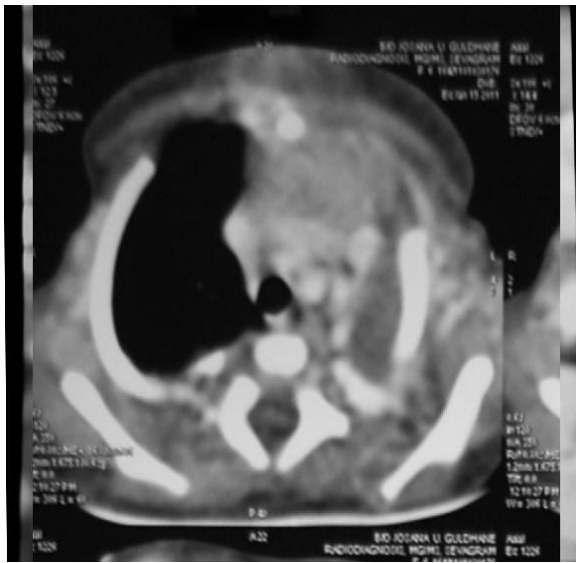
A computed tomography scan of chest - left upper lobe with multiple non enhancing variable sized fluid attenuation cystic area within with similar soft tissue density enhancing area in the perihilar region in the left lower lobe – Congenital Cystic Adenomatoid Malformation (Type-2).
